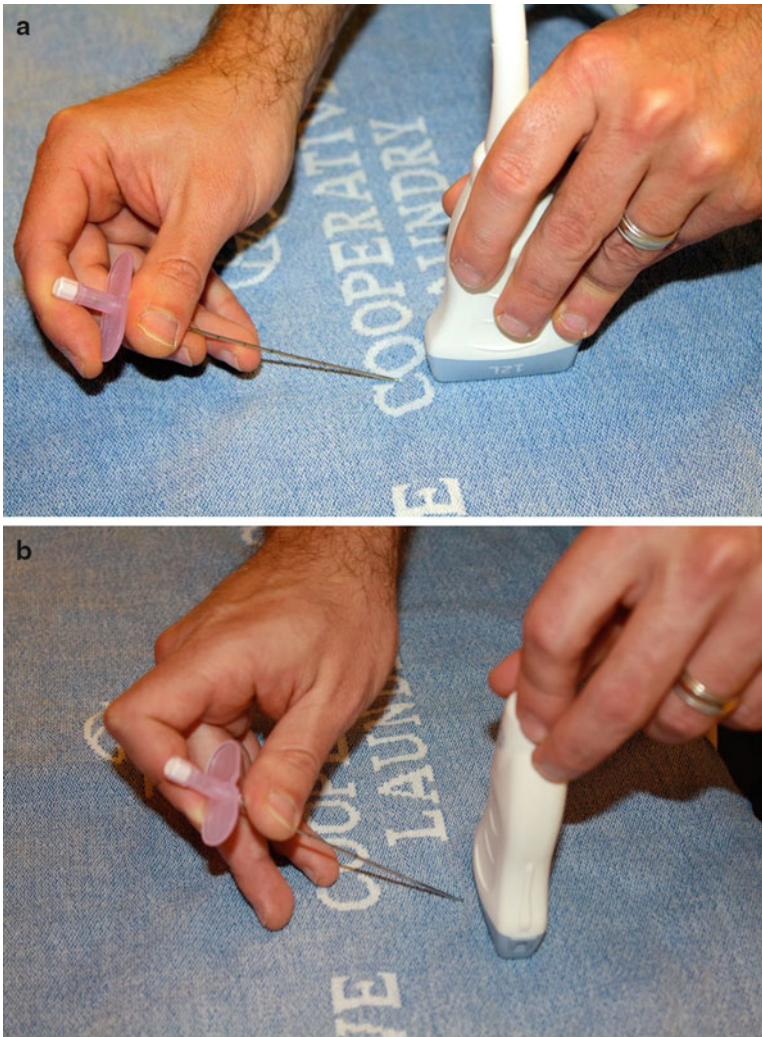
(a) The needle is in-plane with the ultrasound probe. (b) The needle is out-of-plane with the ultrasound probe
